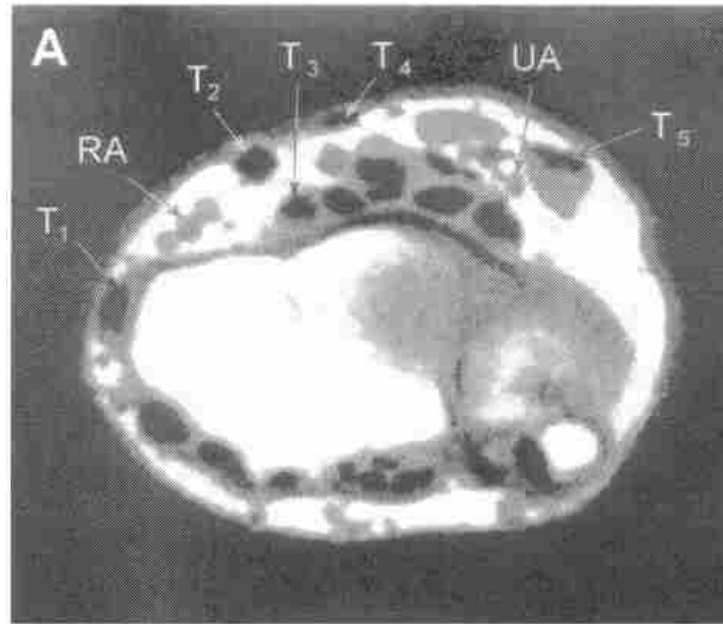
MR image of the right wrist [52]
